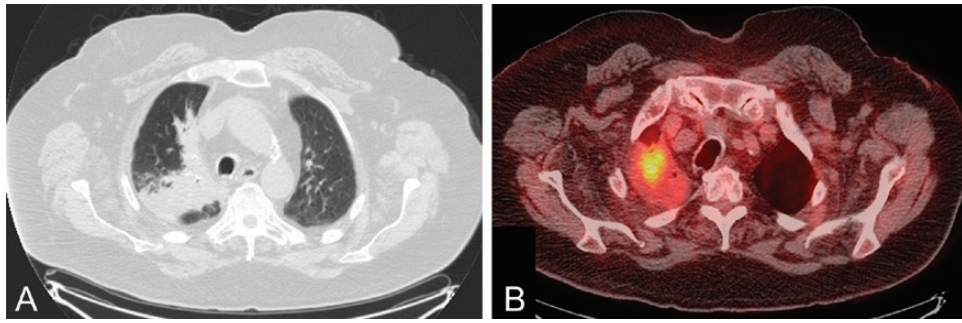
Computerized tomography (CT) scan of the chest showing extensive mass-like consolidative changes in the right upper lobe (A). Positron emission tomography-CT scan showing abnormal fluorodeoxyglucose uptake in the entire lesion, most marked within the pulmonary apex (B).
